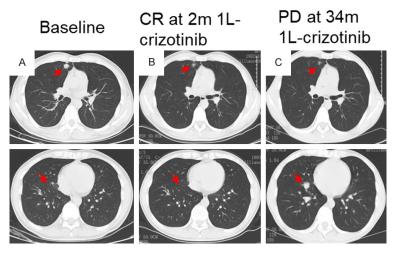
Computed tomographic (CT) images of the patient at baseline (A), at evaluation of complete response (CR) after two months of first-line (1 L) crizotinib therapy (B), and at evaluation of progressive disease (PD) at 34 months of 1 L crizotinib therapy due to enlargement of one of the lung lesions (bottom panel, C). Red arrows indicate the lesions.
